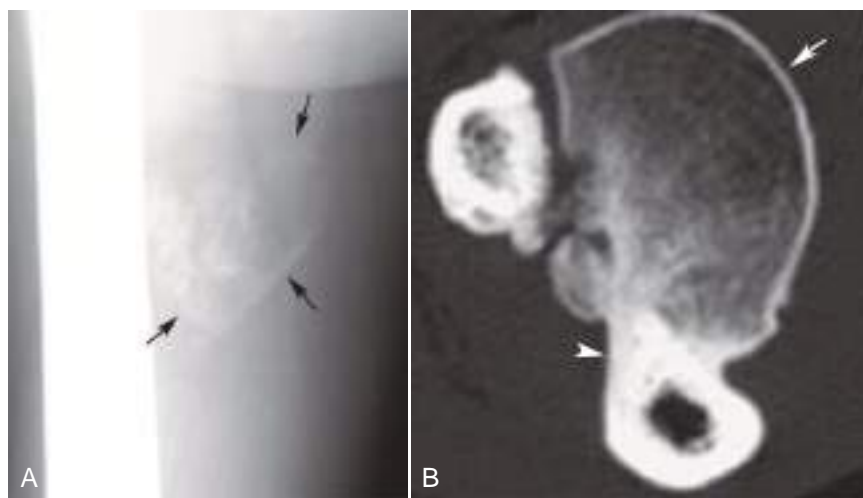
Myositis ossificans. (A) AP radiograph of the right midhigh shows calcification that is densest at the periphery (arrows). (B) Axial CT image in a different patient with myositis ossificans in the forearm shows mature ossification with cortex and trabeculae (arrow) that is fusing with the ulna (arrowhead). (A reprinted with permission from May DA, Disler DG, Jones EA, et al. Abnormal signal within skeletal muscle in magnetic resonance imaging: patterns, pearls, and pitfalls. *Radiographics*. 2000;20:S295-S315. B courtesy of William Pommersheim, MD.)
